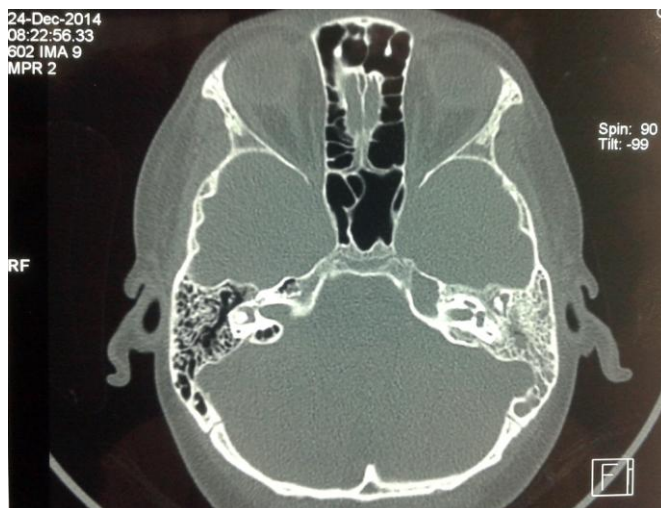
Axial CT scan showed soft tissue opacity of the middle ear, mastoid and petrosal apex on the left side.
